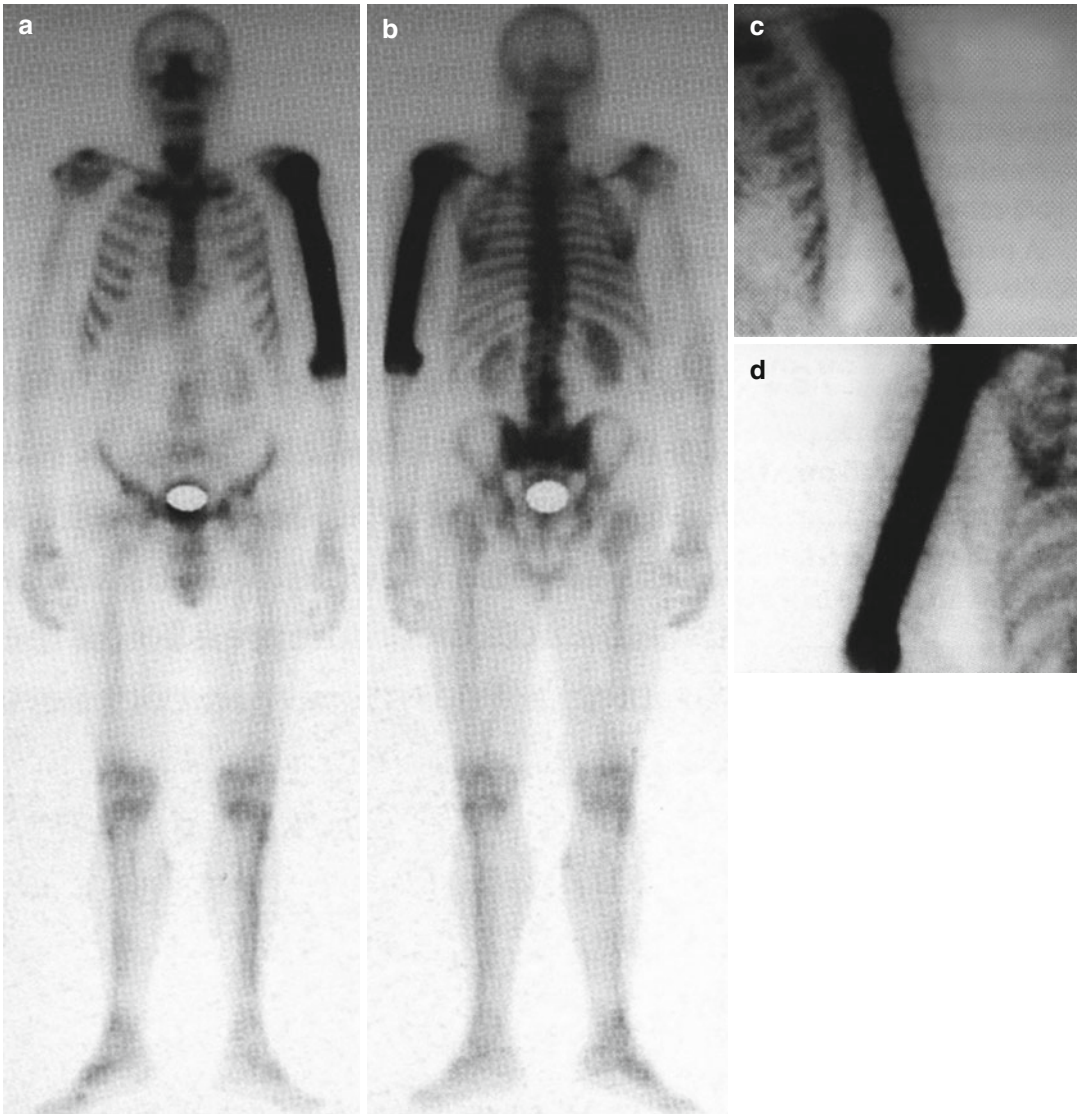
A 56-year-old patient, whole-body bone scintigraphy shows diffusely increased uptake in the left humerus (monostotic form). (a, c) Front view, (b, d) rear view
